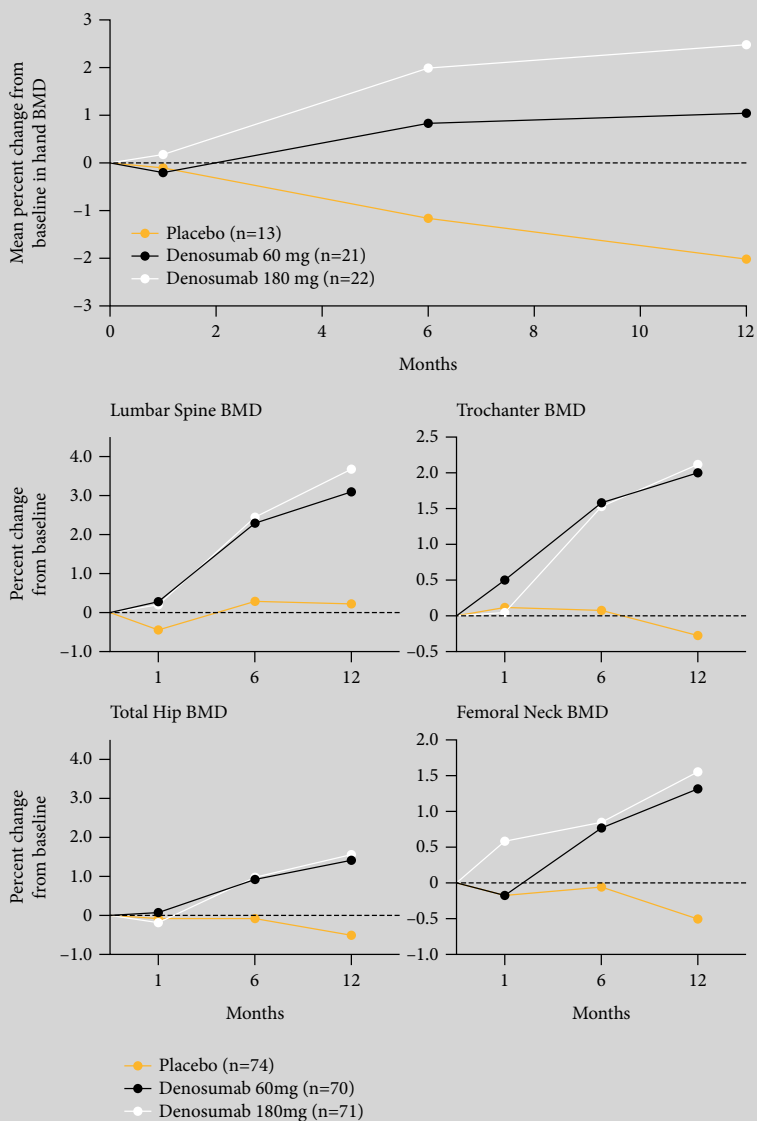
Denosumab reverses bone loss (as measured by dual energy X-ray absorptiometry) in hands, lumbar spine, and femoral neck in patients with rheumatoid arthritis. Denosumab, an anti-receptor activator of nuclear factor κ B ligand monoclonal antibody, inhibits periarticular and systemic bone loss in hand, lumbar spine, and hip in patients with rheumatoid arthritis. BMD, bone mineral density. Adapted with permission from Deodhar et al [29] and Dore et al [31].
